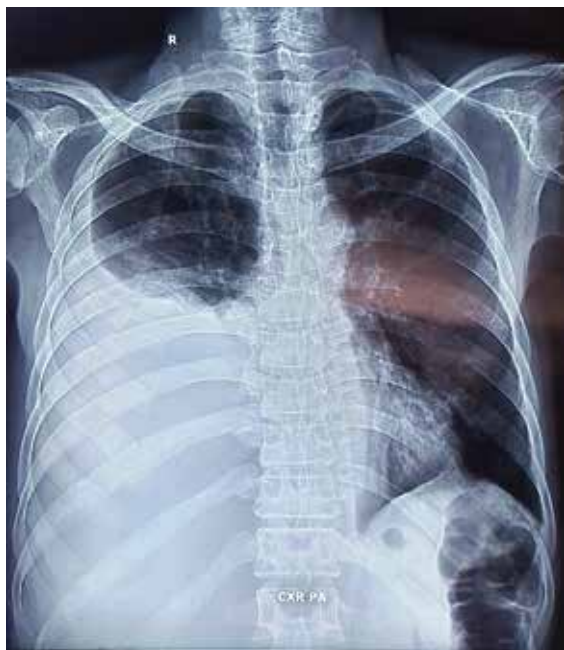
Chest X-ray (posteroanterior view erect posture) demonstrates a large right-sided pleural effusion with homogeneous opacity in the right lower lung zone and obliteration of the right costophrenic angle. The mediastinum appears slightly shifted to the left, with partial compression of the underlying right lung.
